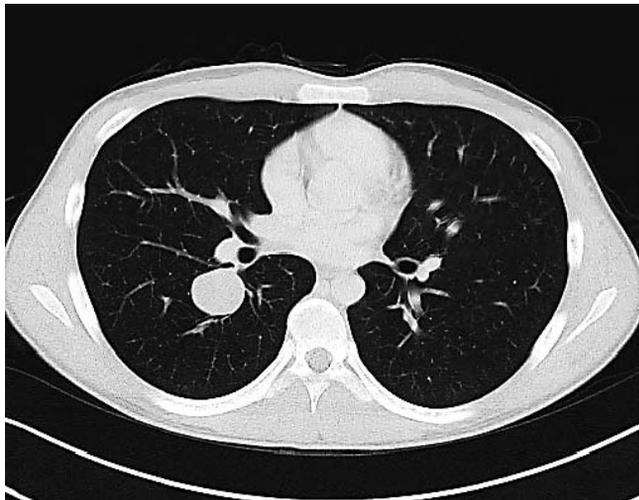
Preoperative chest computed tomography image shows a 3-cm mass with a clear boundary in S6 of the right inferior pulmonary lobe. No infiltrative change was noted.
